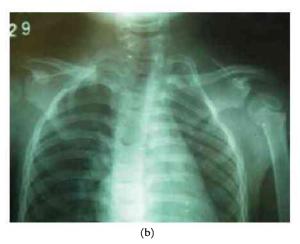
(a) Clinical photo of Sprengel's shoulder (left side). (b) X-ray of the chest showing Sprengel's shoulder (left side).
